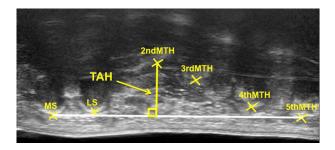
Ultrasound image of transverse arch height (TAH) using the weight-bearing plantar ultrasound imaging device (WPUID).
